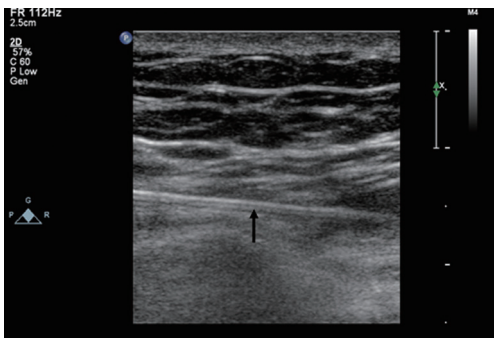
Transthoracic echocardiography showed one needle (arrow) was inserted through the chest wall into the pericardial space.
